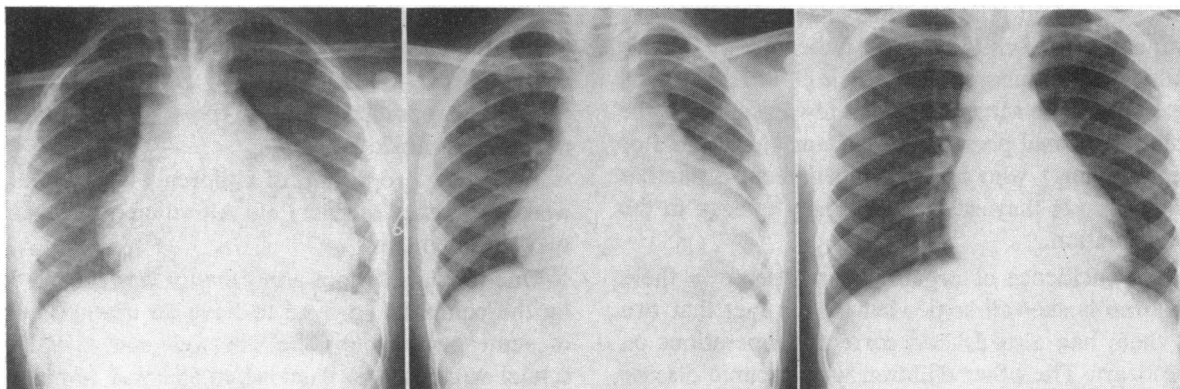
X-ray films of chest taken on the first (left), third (center) and ninth (right) hospital days, showing evolution of the pericardial effusion.
